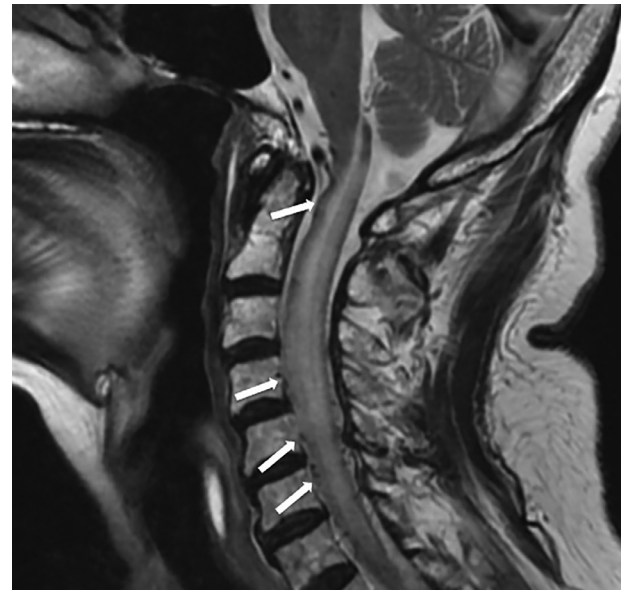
The preoperative MRI T2 weighted sagittal image showing swelling of the spinal cord. Abnormal flow void signals (arrows) were detected in the subdural space of the ventral cervical cord. MRI, magnetic resonance imaging.
